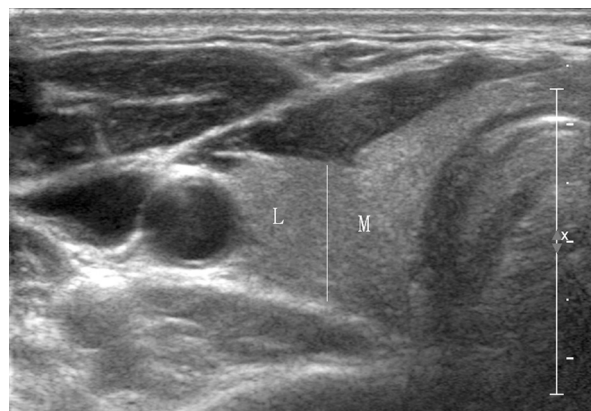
Ultrasonographic axial view of the right thyroid lobe. The axial view of the right lobe was equally divided into the medial (M) and lateral (L) portions.
